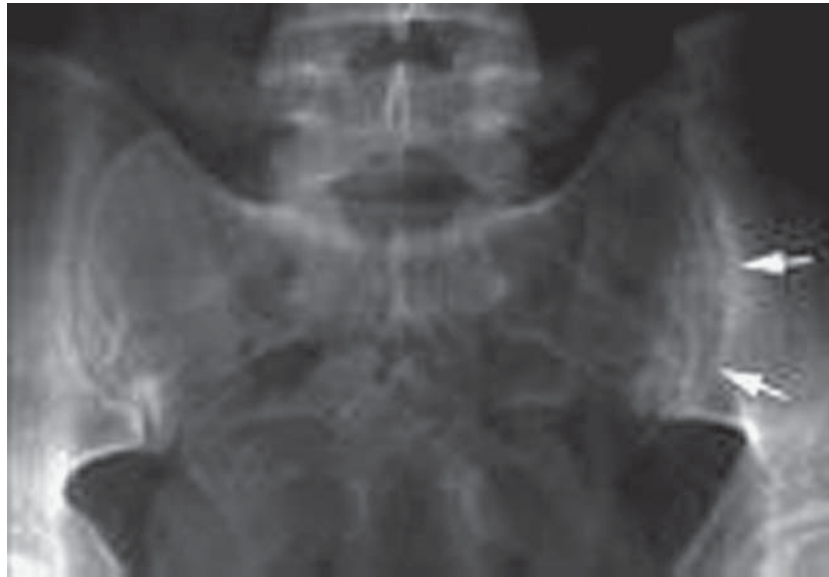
X-ray showing sacroiliitis.
